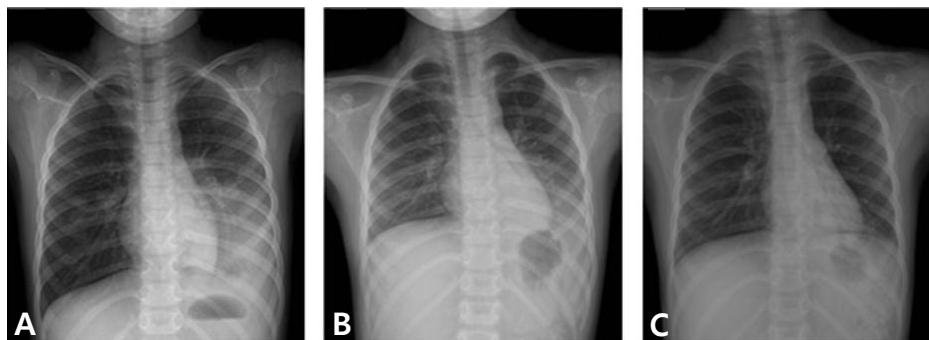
Radiologic findings in a child with severe refractory *Mycoplasma pneumoniae* pneumonia. Chest radiography showed a massive left lower lobar consolidation with pleural effusion before steroid therapy (A), decreased consolidation with scanty pleural effusion at one week after steroid therapy (B), and cleared consolidation at discharge (C).
